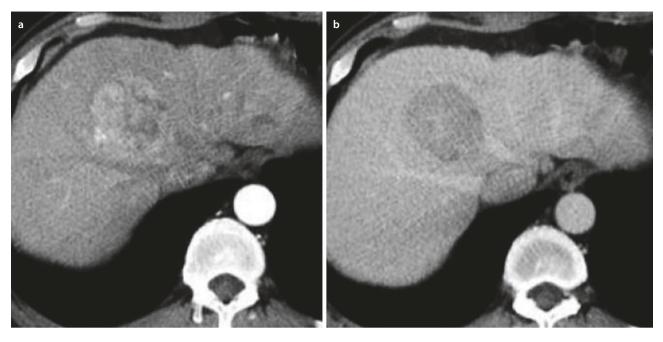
HCC CT-scan. a Arterial phase sequence with wash in and b washout
